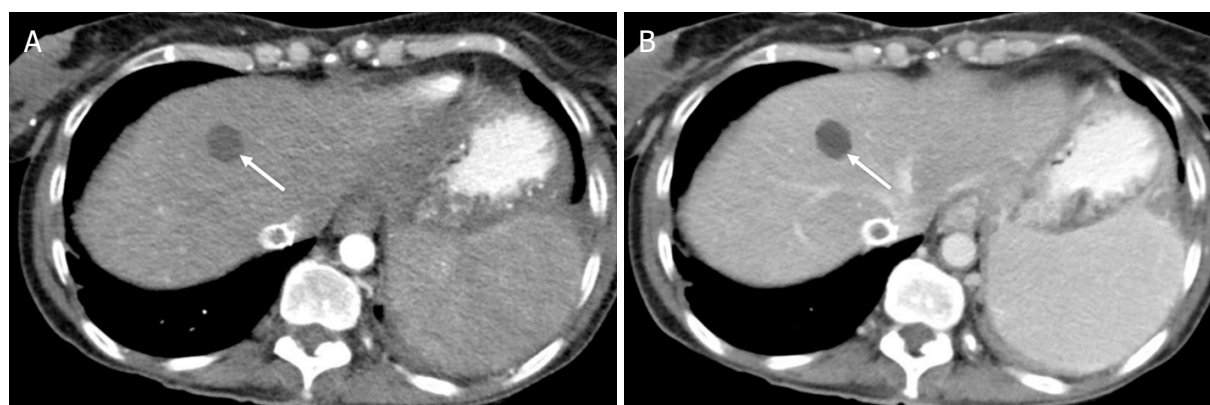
LR-1 (Definitely benign). Axial computed tomography in a 53-year-old woman with hepatitis C cirrhosis. Arterial phase (A); and portal venous phase (B) demonstrate a 17-mm well-defined round observation (arrow) with attenuation values of simple fluid, consistent with a definite simple cyst
